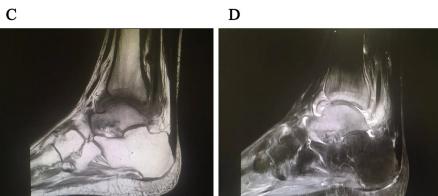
A 32-year-old female patient with *Mycobacterium tuberculosis* infection of the right ankle joint. (A) Swelling and pigmentation of the right ankle joint. (B) Computed tomography (CT) of the right ankle joint: reduced bone density below the articular surface (red arrowhead) and swelling of the joint capsule and soft tissue. (C) Sagittal magnetic resonance imaging (MRI) T1-weighted image. (D) Sagittal MRI T2-weighted image with fat suppression demonstrates diffuse bone marrow edema in the tibia, fibula, and talus, accompanied by thickened and swollen synovium.
